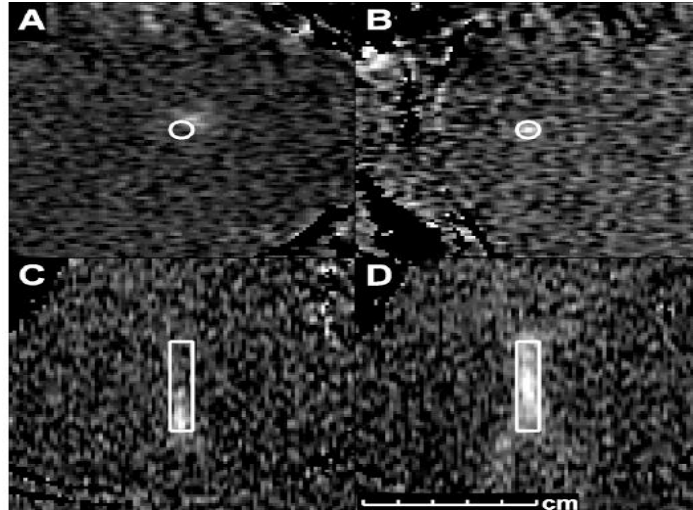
Temperature images acquired during sonication to evaluate targeting. A and B: Images acquired before correcting focal coordinate; C and D: images acquired after correction. A and B: images acquired with temperature imaging perpendicular to the ultrasound beam direction. C and D: images acquired with temperature mapping along the beam direction [18].
